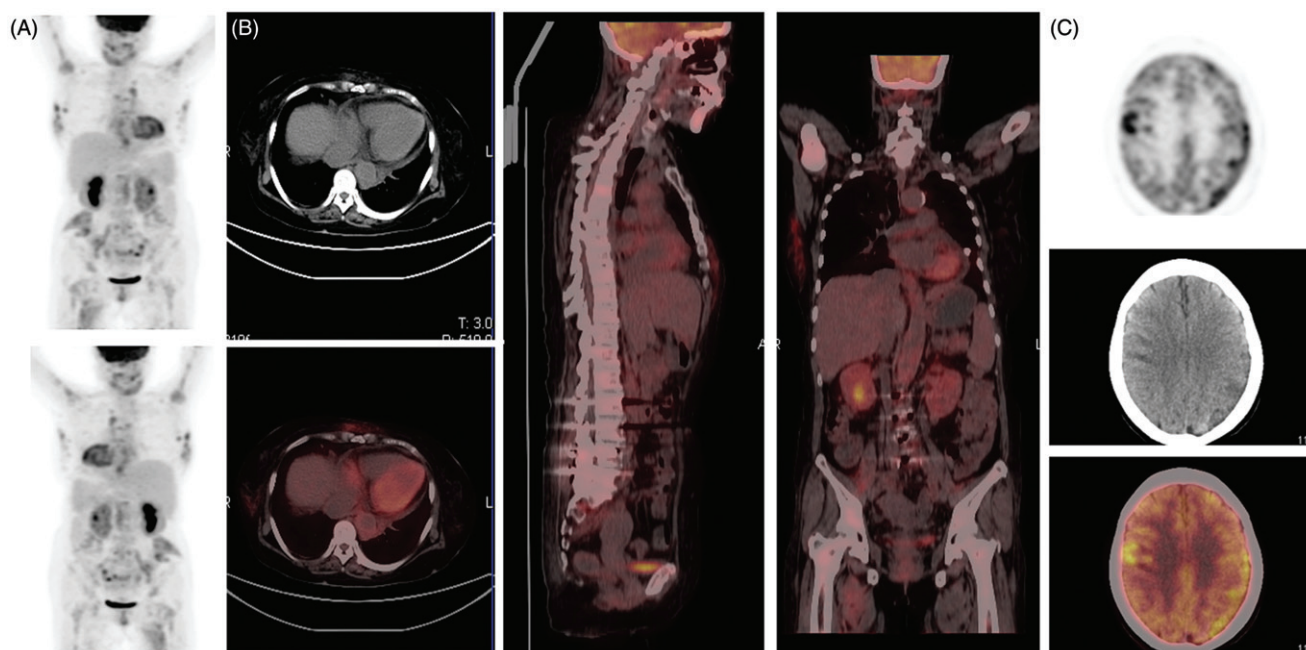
Evaluation of the disease activity after treatment with adalimumab for 3 months. 18F-FDG PET/CT examination of the patients in (A) three-dimensional whole body scan in anterior and posterior views; (B) cardiac system and whole body in lateral and anterior views; (C) brain.
